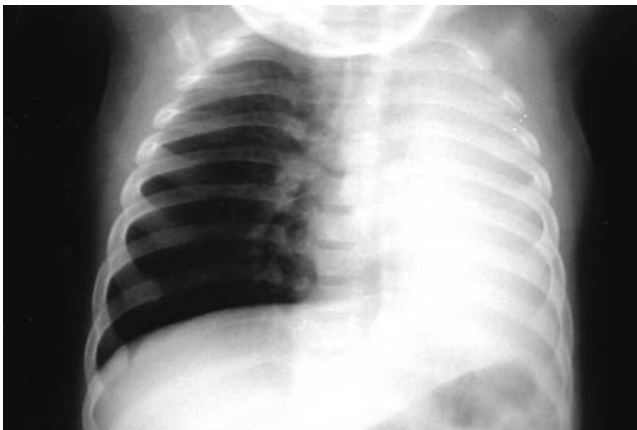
Admission mobile supine chest radiograph showing complete opacification of the left hemithorax, mediastinal deviation to the left and an over-expanded right lung herniating across the midline.
